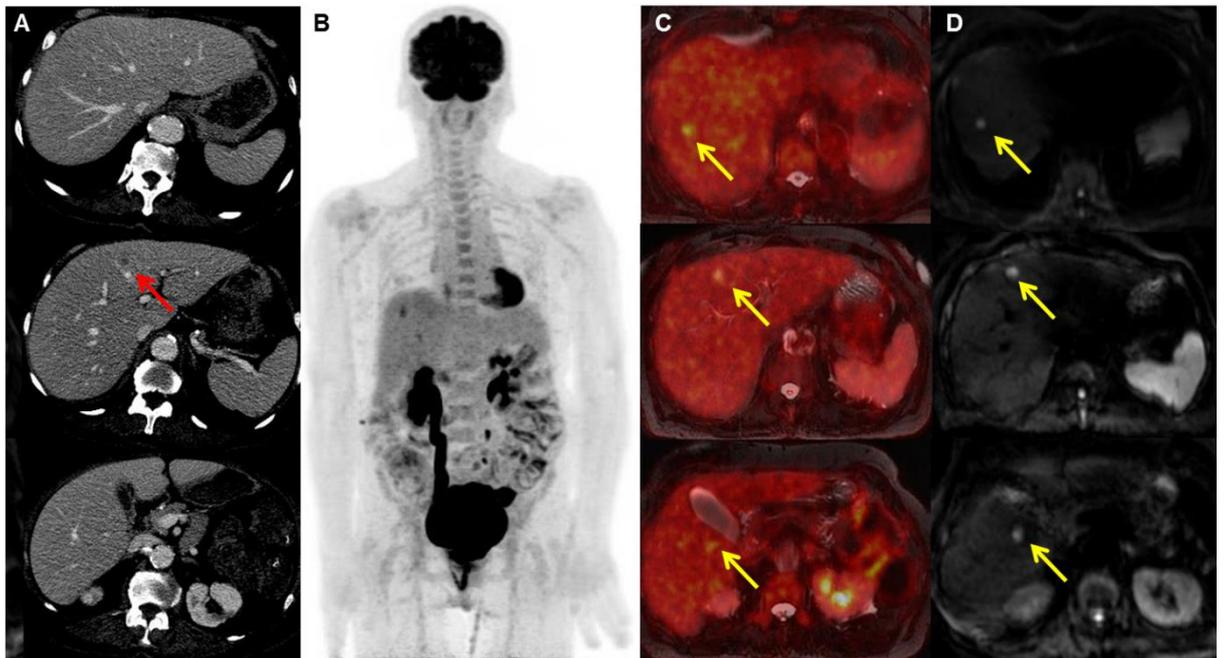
PET/MRI is superior to CS for upstaging from M0 to M1 in the liver and for clarifying indeterminate lesions detected by CS. The patient was a 61-year-old woman, and abdominal ceCT revealed one indeterminate liver lesion (A; red arrow). PET/MRI revealed that this lesion was positive with restricted diffusion and high FDG uptake (C–D; yellow arrows). PET/MRI also revealed two other liver lesions with similar characteristics (C–D; yellow arrows). These lesions were confirmed by imaging follow-up.
